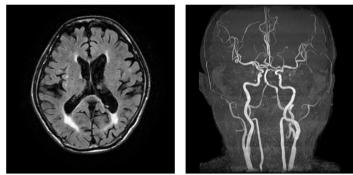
Brain MRI and MRA. a: MRI finding b: MRA finding
